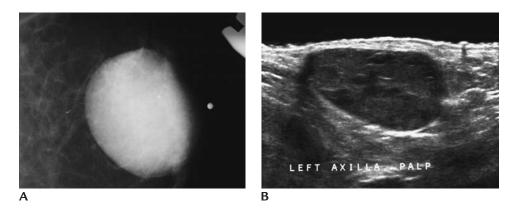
Sebaceous cyst. (A) Spot tangential compression view of a palpable mass in the left axilla demonstrates an oval high density mass with circumscribed margins and a solitary round calcification. Metallic BB used by technologist to mark palpable finding. These lesions can occur anywhere; however, they are more common in the inner quadrants and axillary regions. (B) On ultrasound an oval, complex cystic mass is imaged corresponding to the superficial readily palpable mass associated with the skin.
